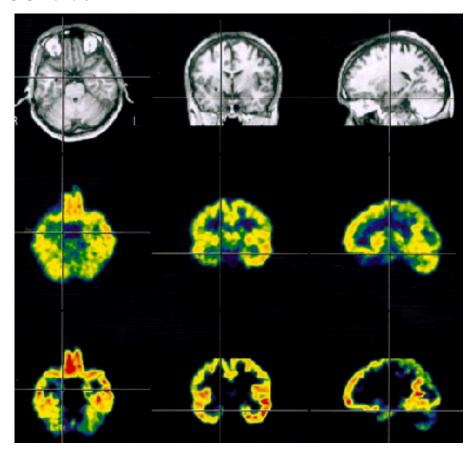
The top row shows three sections through a T1-weighted MRI of a subject with onset of seizures in the right temporal lobe (left side of the figure). 1T MRI was normal. The second row shows a coregistered ¹⁸FDG PET; extensive right temporal hypometabolism is demonstrated. However, the bottom row depicts ¹¹C-flumazenil PET from the same subject; the region of reduced flumazenil binding is much more restricted, confined only to the right mesial temporal structures. From: Szelies *et al. MRI-Guided Flumazenil- and FDG-PET in Temporal Lobe Epilepsy Neuroimage* 1996: 3; 109–118 (Fig. 3(a)). Copyright Academic Press 1996, used with permission.
